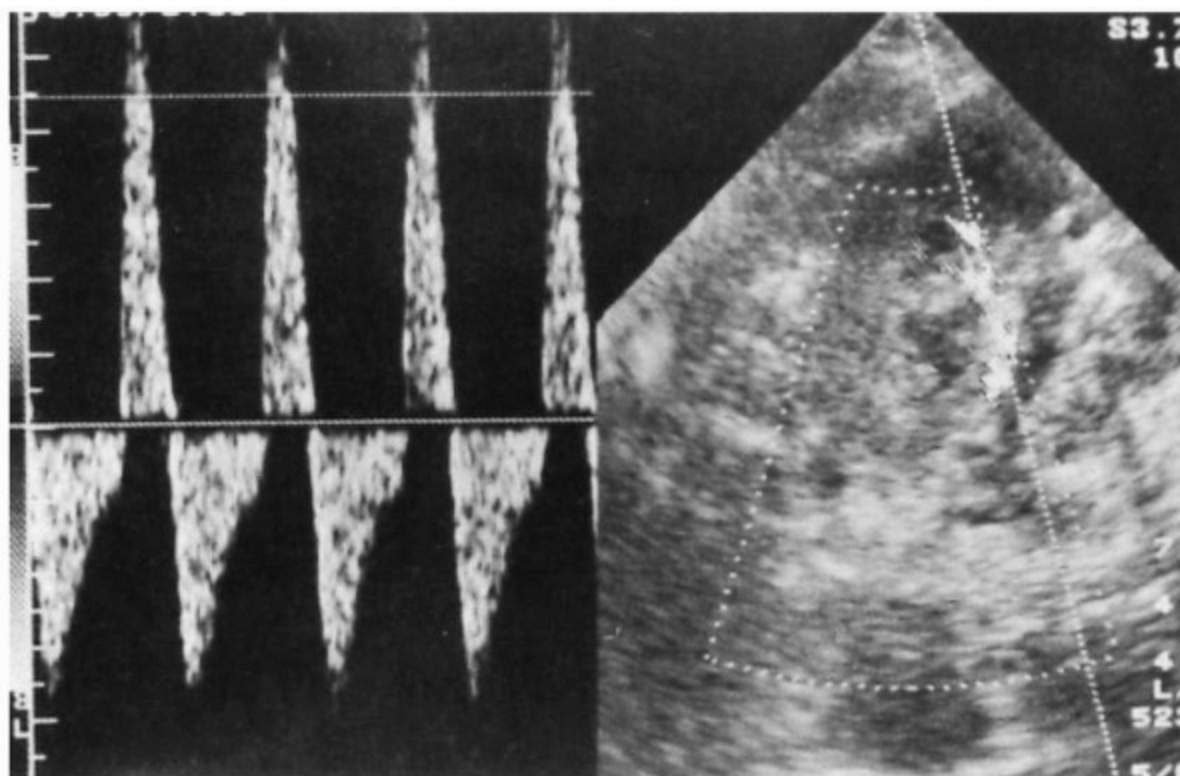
Duplex sonogram of transplant renal vein thrombosis demonstrates reversed flow in diastole and a spikelike systolic peak. No venous flow was
